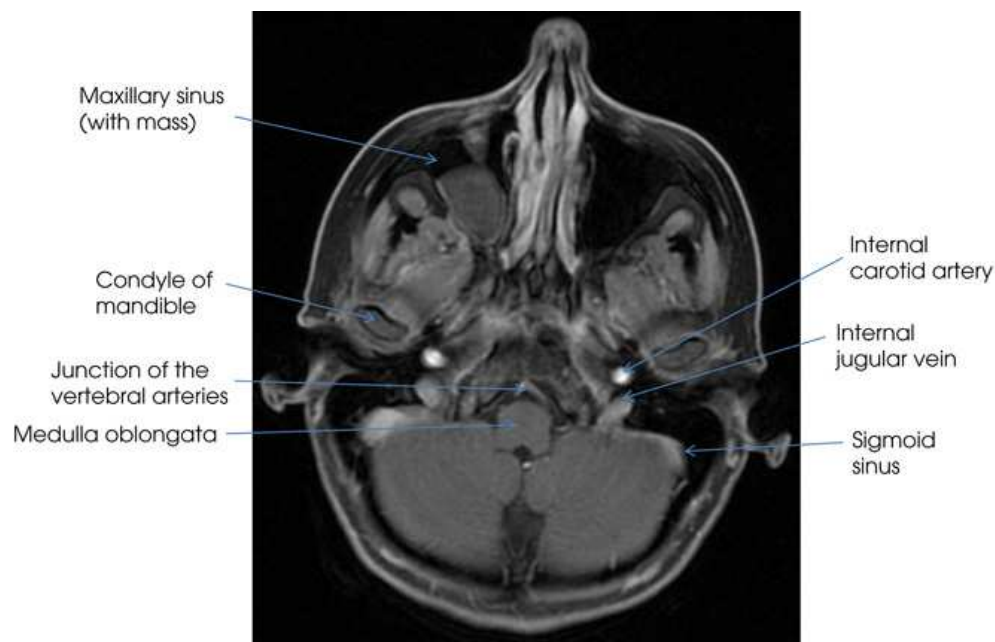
MRI representing anatomic structures located at level *F* in Fig. 24.5B.
